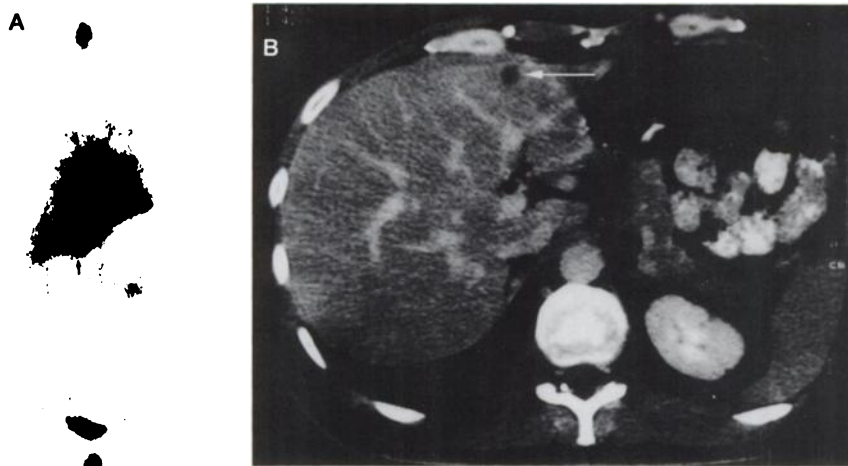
Patient 8. Anterior view (A) of the body scan recorded 5 hr after ^{111}In -diDTPA-TL injection clearly shows liver recurrence (arrow) not visualized by a previous CT scan. A second CT scan performed after immunoscintigraphy (B) confirmed a 10×10 -mm recurrence (arrow).
